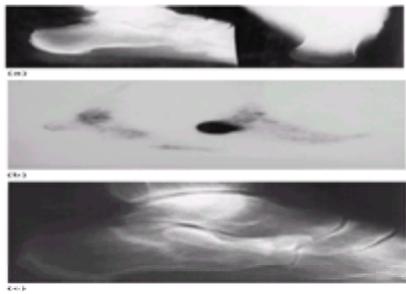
Occult fracture of the calcaneum. (a) The initial radiograph shows no abnormality but a radioisotope bone scan (b) shows a gross increase in uptake in the calcaneum. (c) Another patient showing a stress or increment fracture in an osteoporotic calcaneum, seen as a serpiginous dense line extending to the upper cortex of the bone and reaching it at a right angle.
